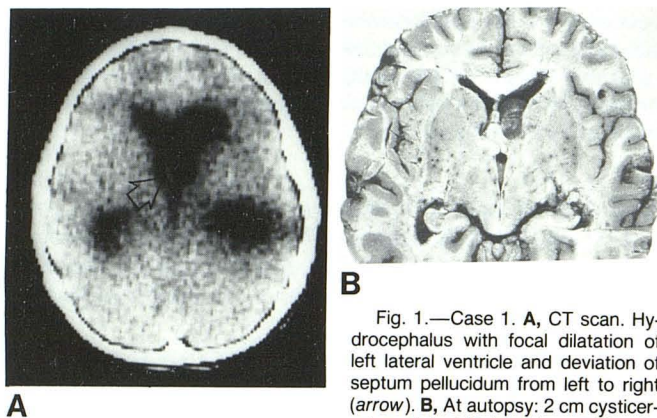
Case 1. A, CT scan. Hydrocephalus with focal dilatation of left lateral ventricle and deviation of septum pellucidum from left to right (arrow). B, At autopsy: 2 cm cysticercal cyst in left lateral ventricle obstructing foramen of Monro.
